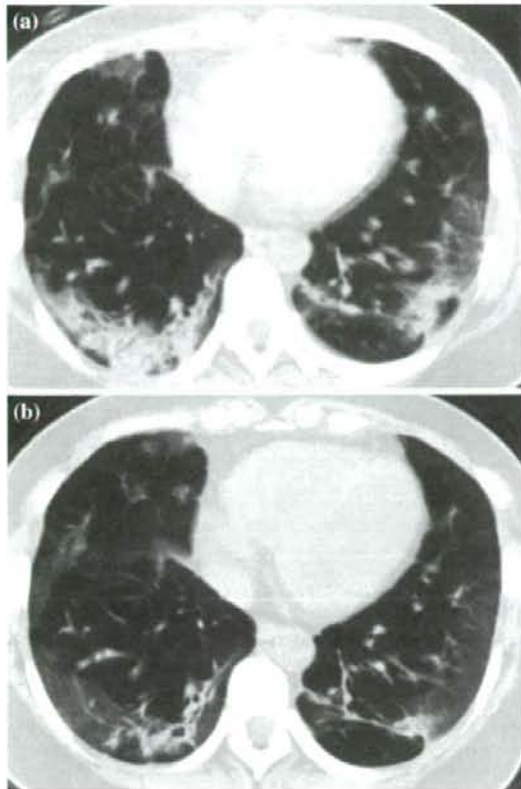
Chest CT scans 2 (a) and 4 (b) weeks after initiating methylprednisolone demonstrating amelioration of interstitial lesions
